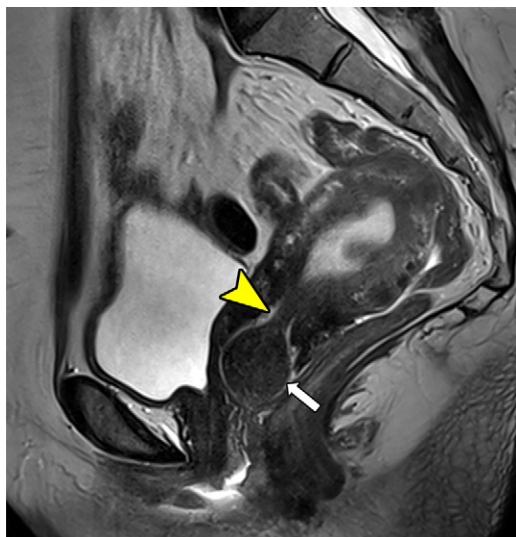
FIGO stage 0 leiomyoma in a 42-year-old woman who presented with heavy menses. Sagittal T2W MR image shows a hypointense pedunculated conventional leiomyoma (arrow) extending from the lower uterine segment into the upper vagina. The thin stalk (arrow-head) can be seen within the endocervical canal. There is also a FIGO stage 1 submucosal leiomyoma partially imaged in the superior aspect of the endometrium.
